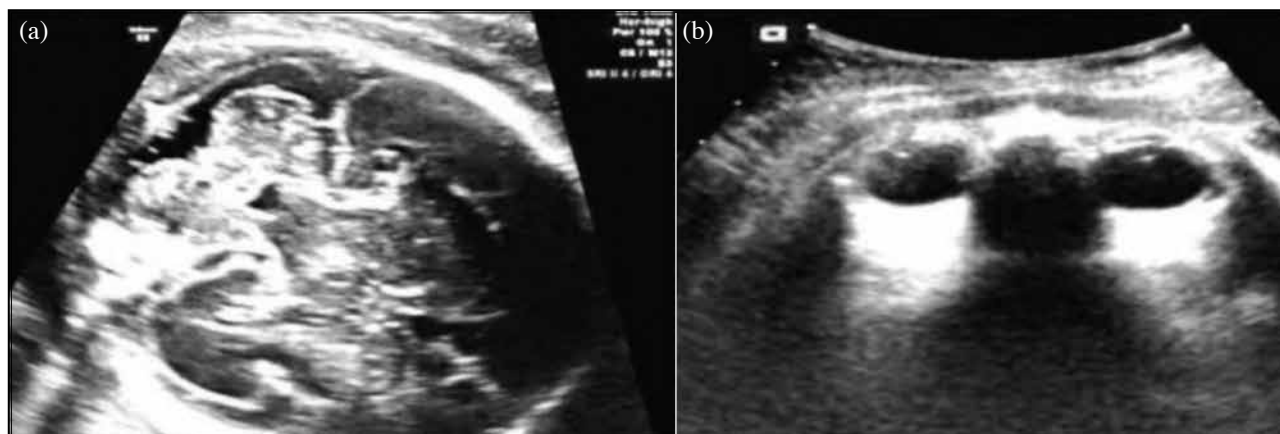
Intrapartum transabdominal ultrasound showing the fetal head position: (a) occiput and cerebellum shown anteriorly in occipital anterior position, and (b) anterior pointing orbits in occipital posterior position (reproduced from ALSO course materials 2020 with permission from ALSO (HK) Advisory Board)
